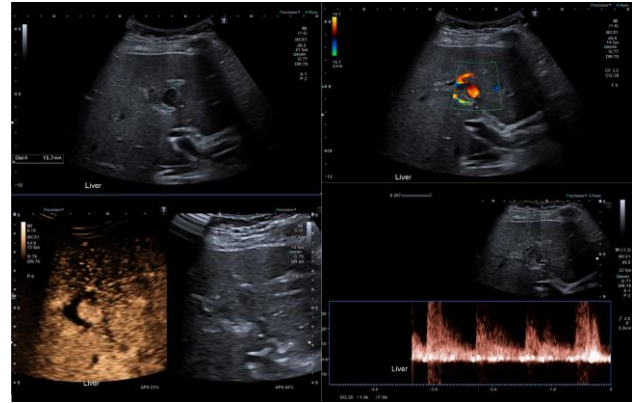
Ultrasound scan of the liver with contrast characterizing and confirming the mycotic hepatic artery aneurysm.
